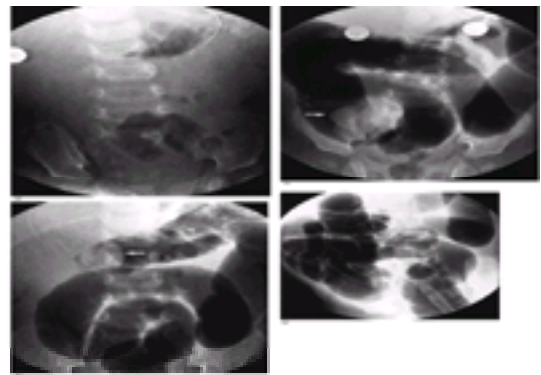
Plain radiograph of infant with an intussusception shows a relatively gasless abdomen (a); rectal insufflation of air outlines the intussusception in mid-transverse colon (arrow) (b); this is reduced to the caecum (c); complete reduction is indicated by reflux of air into small bowel loops (d).
